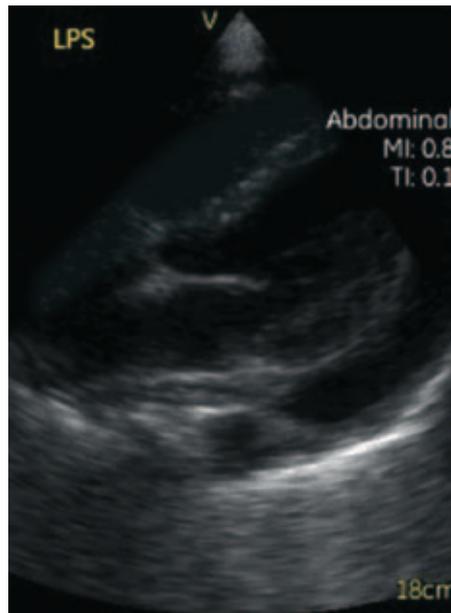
Long Parasternal view of the heart, showing pericardial effusion, surrounding cardiac silhouette
